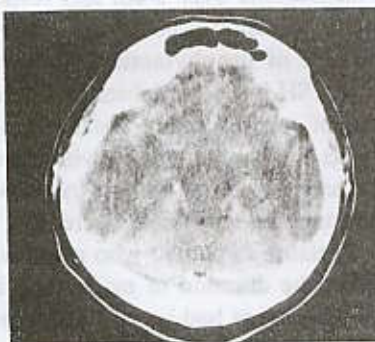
CT brain scan showed markedly diffuse cerebral oedema with compression of the quadrigeminal cistern.
